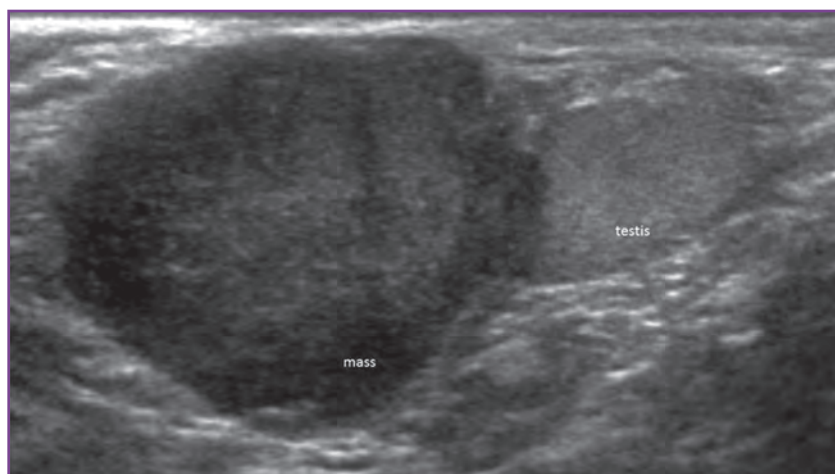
Paratesticular mass identified at scrotal ultrasonography, which turned out to be a paratesticular rhabdomyosarcoma.
